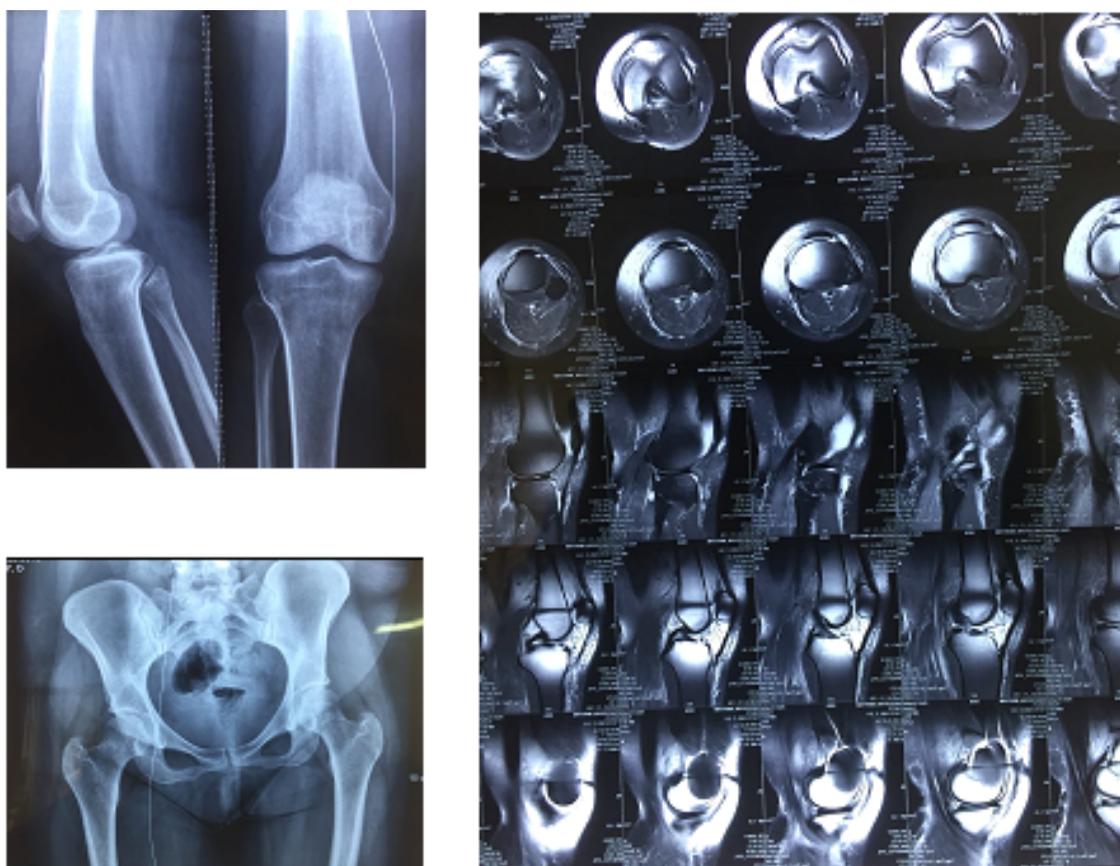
Anterior-posterior and lateral view of right knee, Anterior-posterior view of pelvis, and magnetic resonance imaging of patient's right knee.
